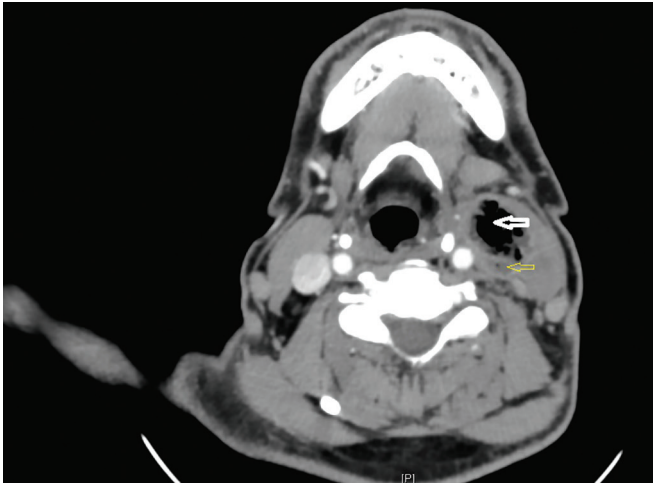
Axial image of contrast-enhanced CT of neck showing a gas-filled abscess cavity (white arrow) adjacent to thrombosed IJV (yellow arrow)
